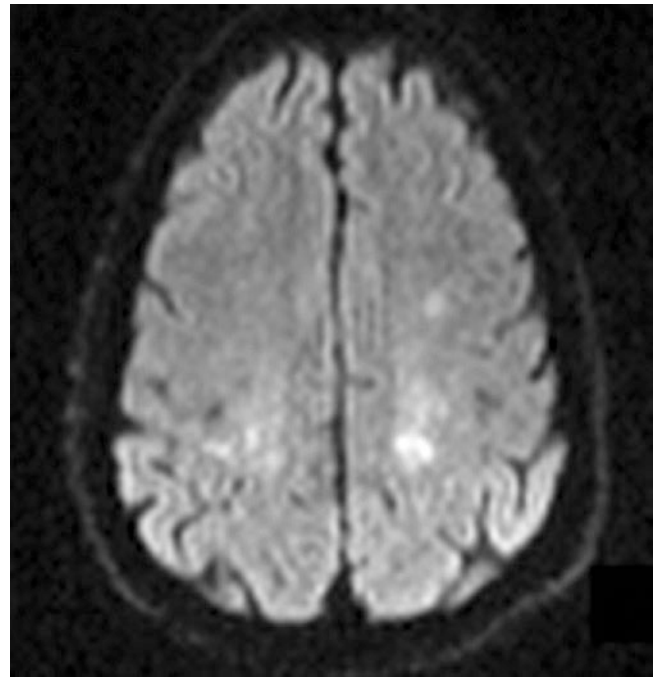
Acute methotrexate neurotoxicity. Patient with recent intrathecal methotrexate for leukemia presents with right-sided weakness and slurred speech. DWI shows diffusion restriction of bilateral centrum semiovale on the left more than on right
